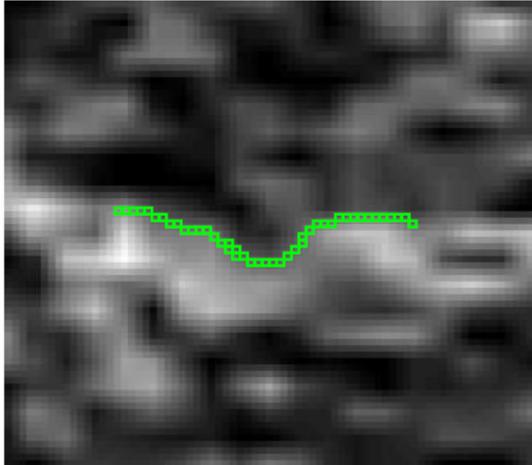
chest CT part, of an image rated as bad image quality
